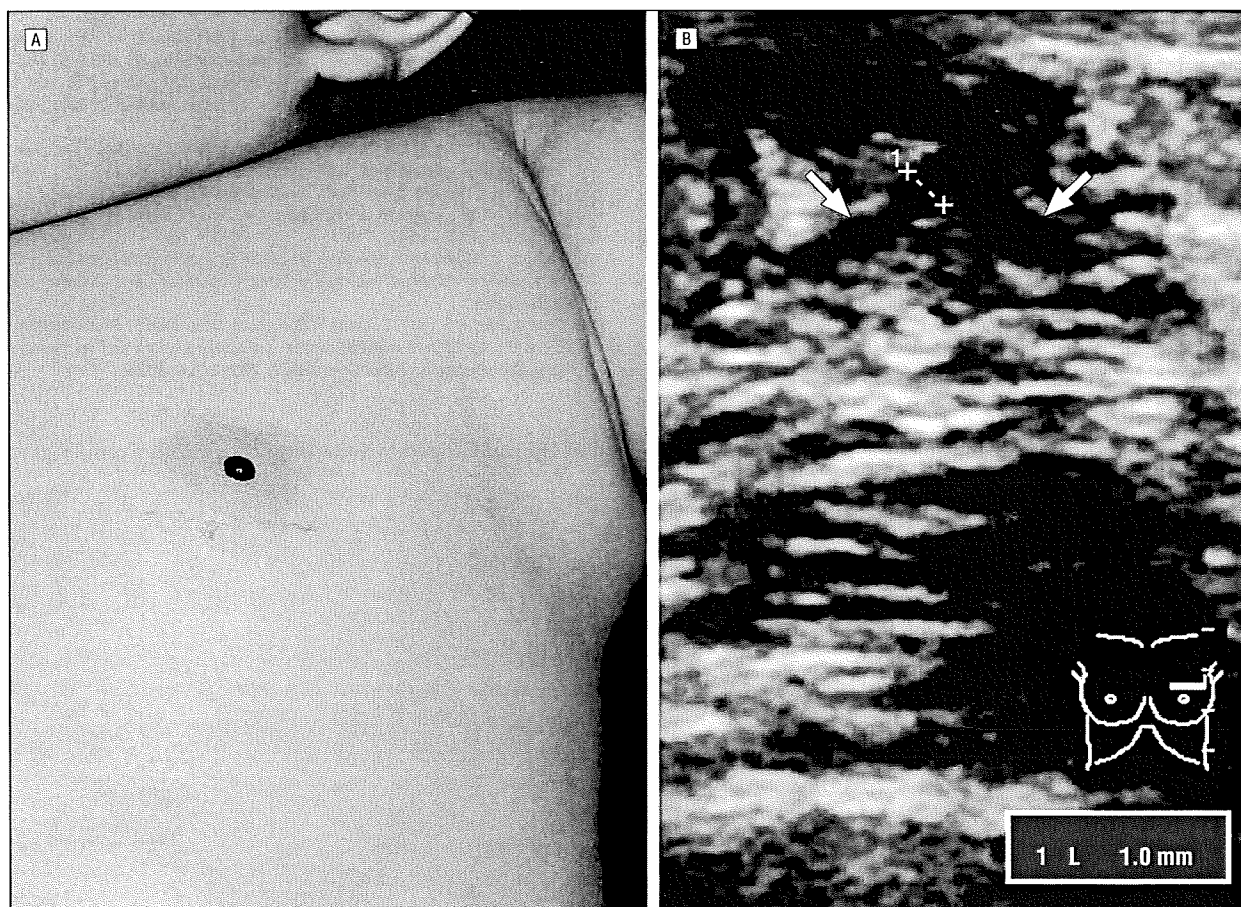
Bloody nipple discharge. A, Clinical appearance of bloody nipple discharge from the left breast. B, Ultrasonographic image of the left breast showing dilatation of the subareolar mammary ducts (arrows).
